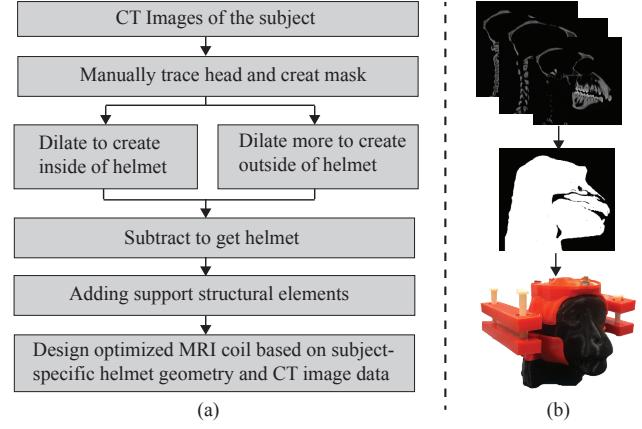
(a) The required steps to convert CT images into a 3D subject-specific helmet. (b) CT images of the subject, headmask and the printed prototype.
